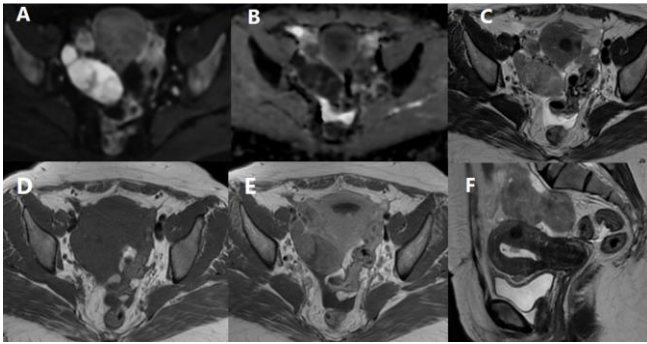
(A) DWI, (B) ADC map, (C) Axial T2, (D) Axial T1 pre-contrast, (E) Axial T1 post-contrast, (F) Sagittal T2 WI show Malignant right ovarian lesion with peritoneal deposits. Right hemi pelvic region large lobulated soft tissue mass lesion, inseparable from the right ovary. Mild right side hydrosalpinx. Minimal free fluid in Douglas pouch. Small endometrial polyp. Posterior uterine wall small interstitial fibroid. It shows a diffusion restriction pattern, a bright DWI signal (A), low ADC map signal (B), intermediate to low signal in T2 WI (C & F), a low signal in T1 (D) with heterogenous post-contrast enhancement (E) The tumor's ADC value is around $0.7 \times 10^{-3} \text{ mm}^2/\text{s}$.
